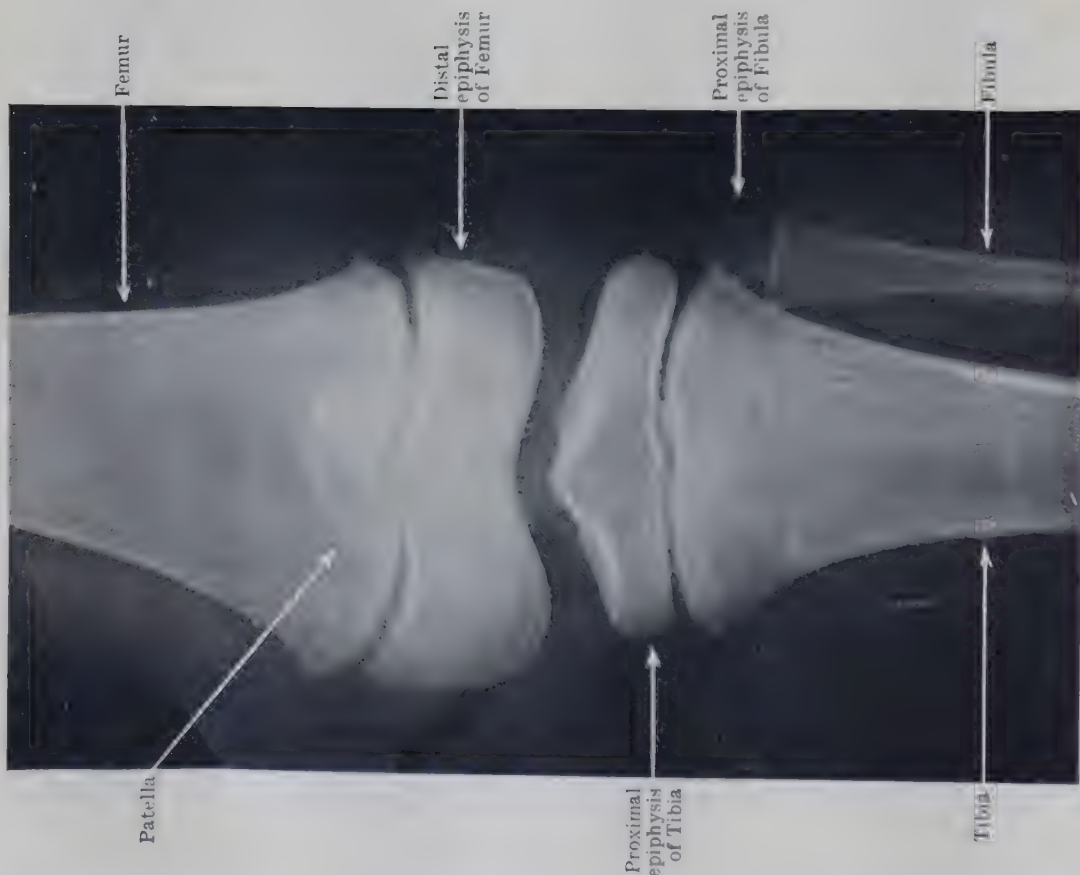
POSTERIOR RADIOGRAPH OF KNEE OF GIRL AGED 7.
